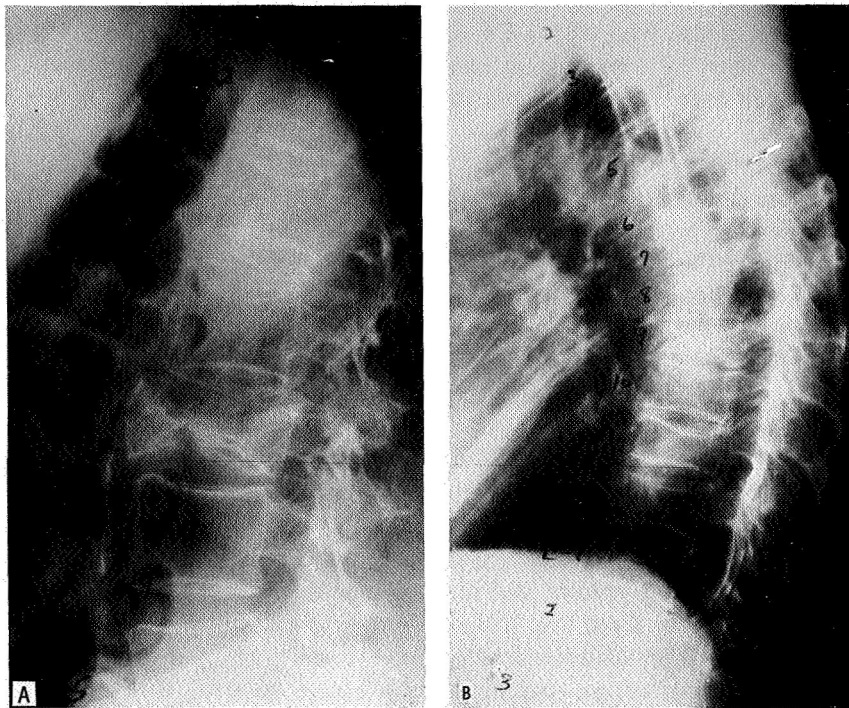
Roentgenographs of osteoporotic spines: (a) Lumbar spine and (b) dorsal spine.
